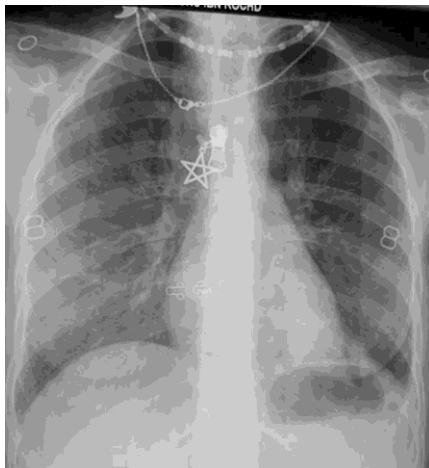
Frontal chest X-ray showing a left basal opacity resting on the diaphragmatic dome with the presence of finely circled lucencies in the left paracardiac and at the level of the upper third of the right hemithorax.
